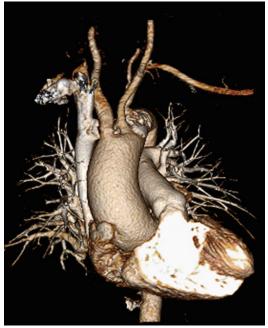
Three-dimensional processed CTA image
